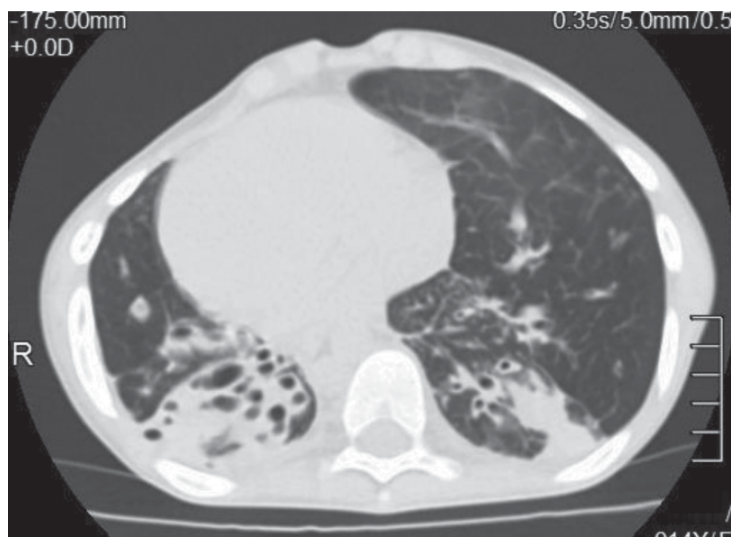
Computed tomography of the *patient C.* Reversed mediastinal organs, CT signs of bilateral chronic bronchopulmonary process were visualized. Bronchiectases with more advanced changes compared to previous investigation made in 2013, especially in the lower lobes
